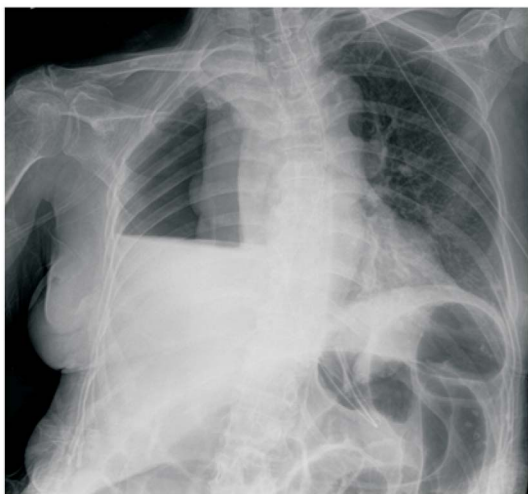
A chest radiograph reveals right hydropneumothorax.
